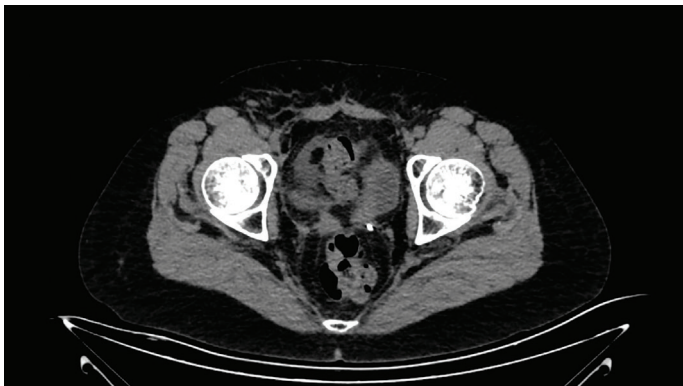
No signs of recurrence were detected on the contrast-enhanced CT scan performed in the 9th year of follow-up
